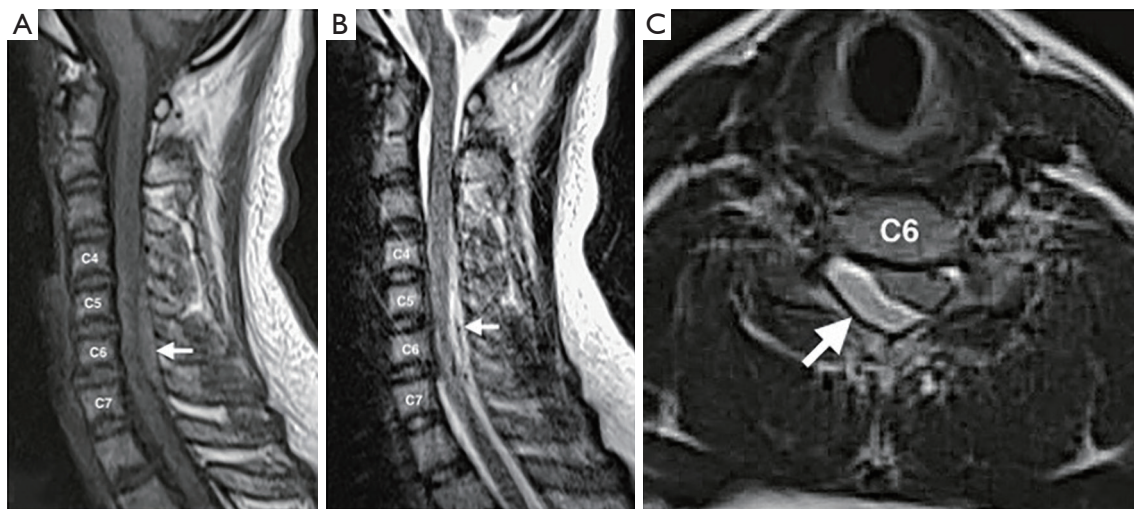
Cervical spine MRI showing SEH (white arrows) from C4 to C7 levels. (A) T1-weighted sagittal view; the SEH appeared isointense. (B) T2-weighted sagittal view; the SEH appeared hyperintense. (C) T2-weighted axial view at the level of C5/6 foramen; the SEH located at the right posterolateral compressing anteriorly the spinal cord to the left. MRI, magnetic resonance imaging; SEH, spinal epidural hematoma.
